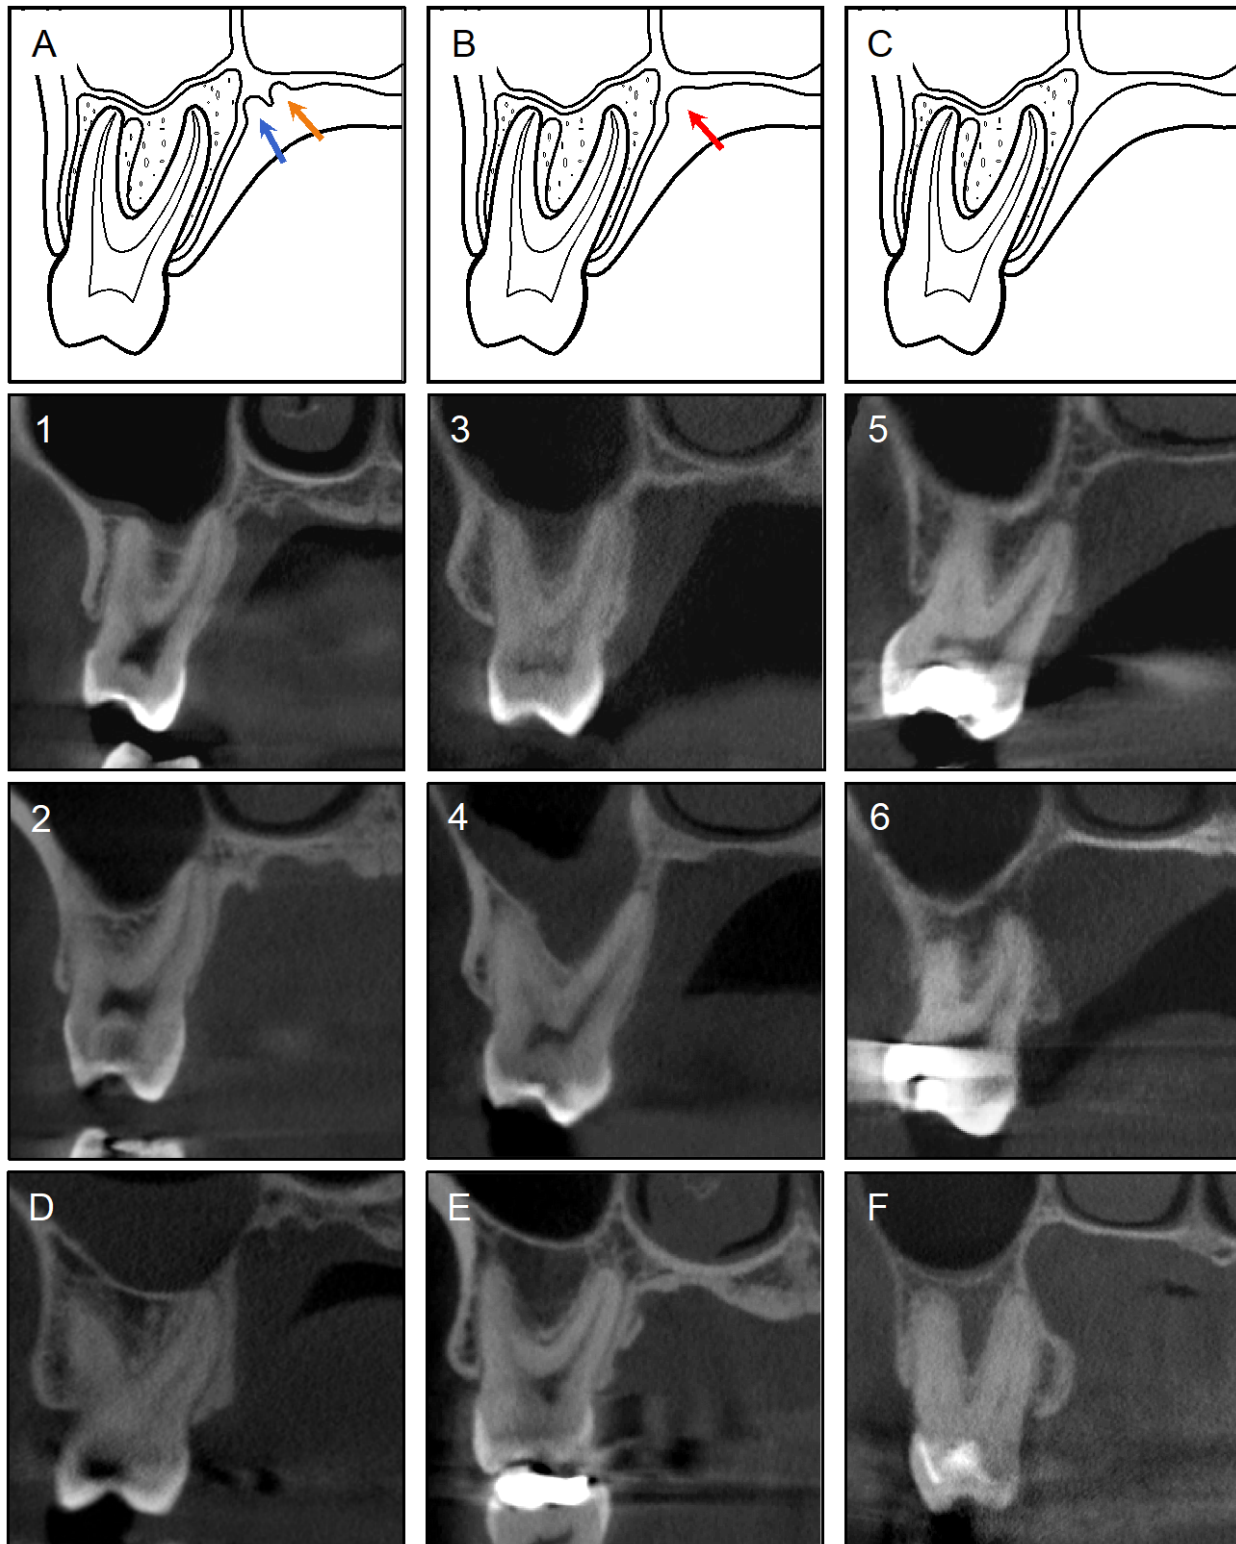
CBCT Coronal Section Palatal Transition Morphology (PTM) Classification
